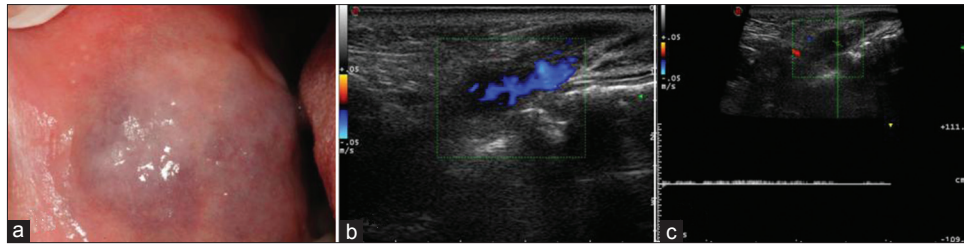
(a) Clinical appearance venous malformation of the right cheek. (b) At color-Doppler US image, the lesion appeared heterogeneously hypoechoic with multiple anechoic sinusoidal spaces (longitudinal plane) with mild vascularization. (c) At spectral analysis monophasic venous flow was detected
